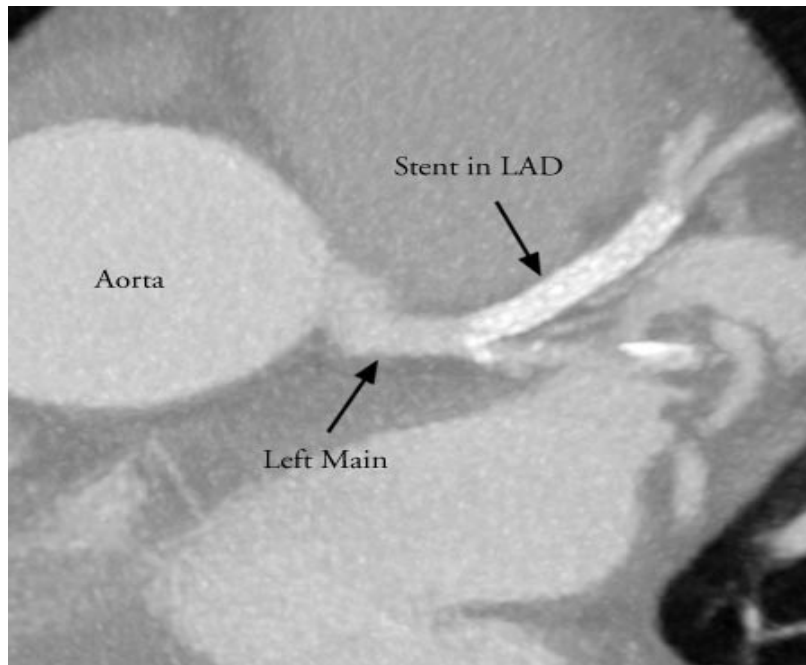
for 52 years old male patient coronary CTA shows stent in the left Anterior.
